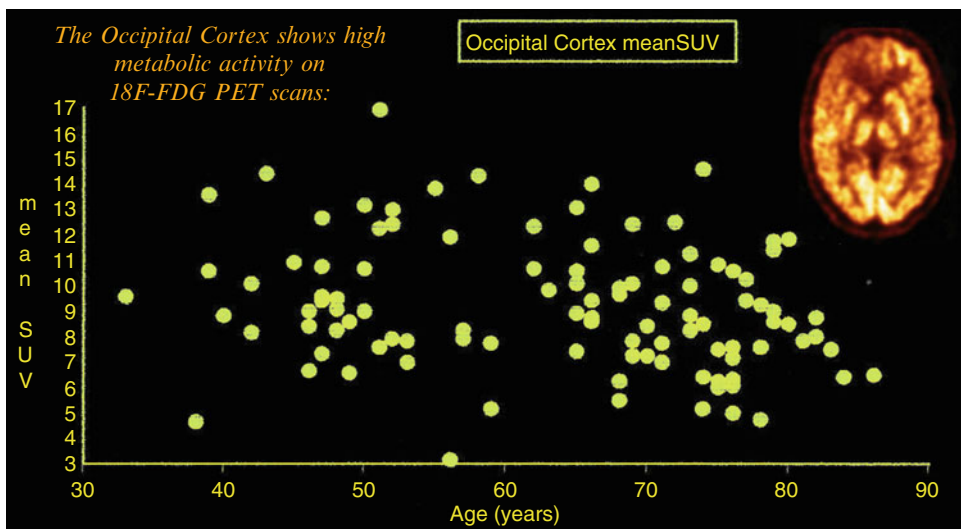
High metabolic rates and correspondingly high FDG uptake levels as reflected by standardized uptake values (SUV) is typical for normal visual cortices with a slight decline with age
